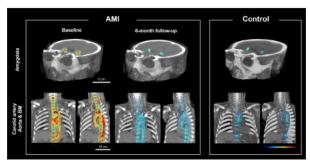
3D-rendered 18F-FDG-PET/CT images representing "brain-hemato poiesis-vascular axis" (Eur Heart J 2021;42(19):1883-95.)
